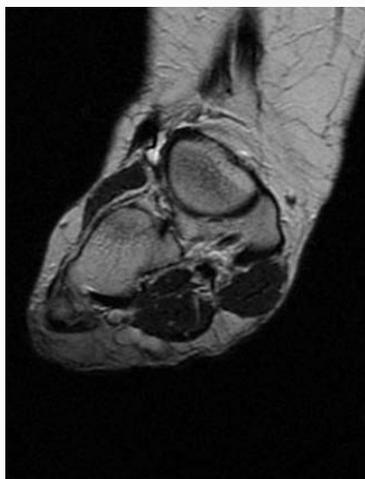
MRI with contrast – right foot - T2 coronal view.
